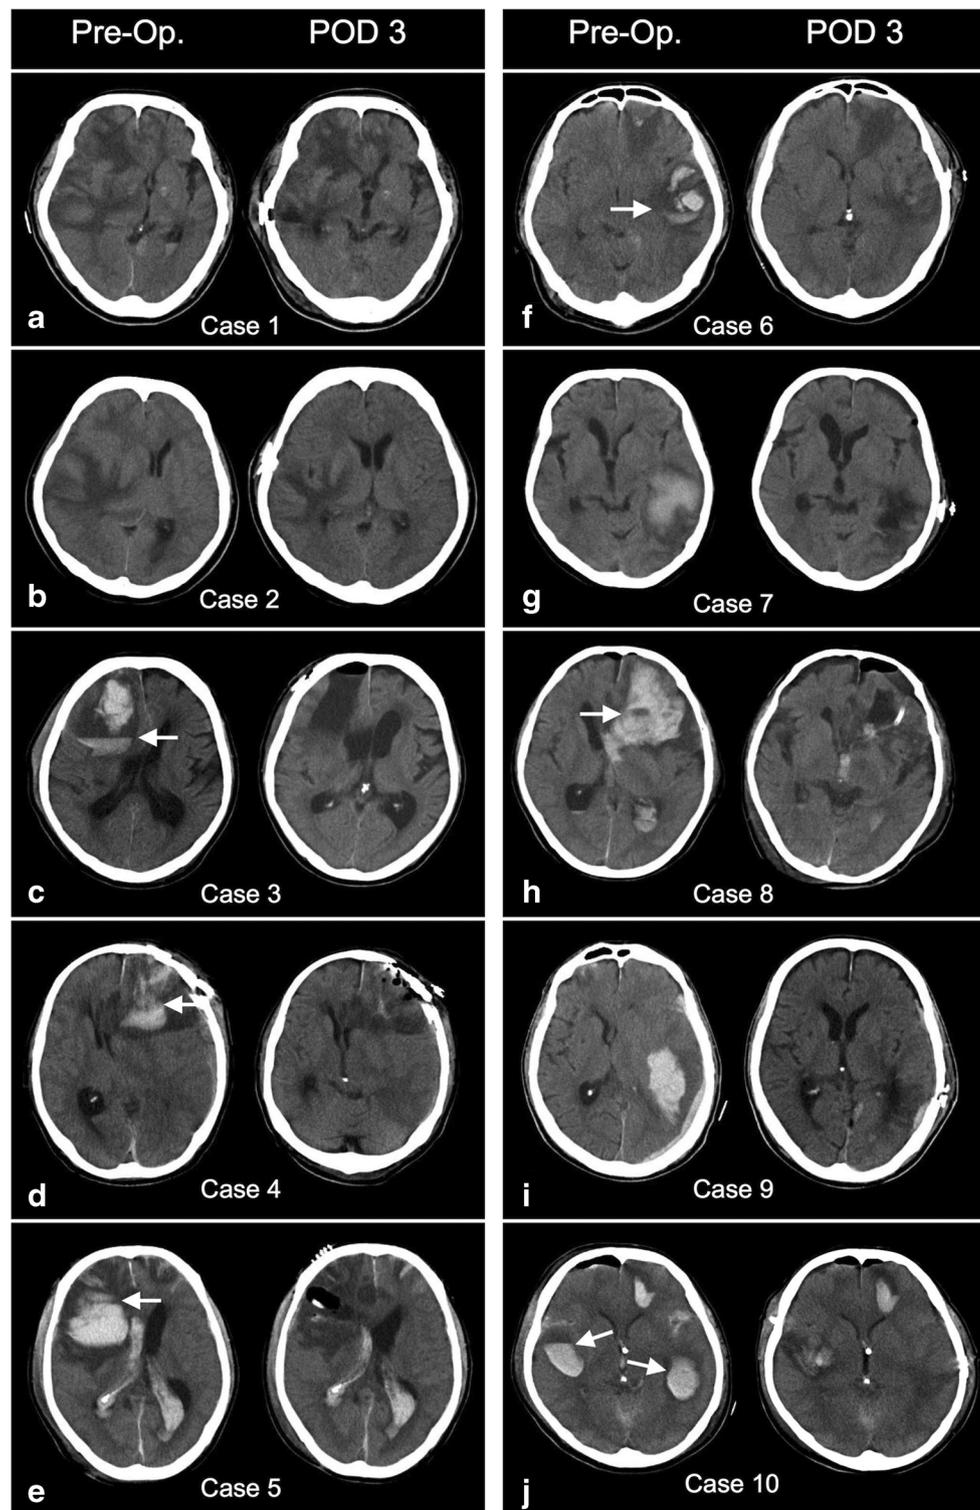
Computed tomography (CT) scans for our present patients taken preoperatively (left) and 3 days after endoscopic surgery (right). Arrows show the blood-fluid interfaces. Sufficient reduction in contusional edema was obtained within 3 days after neuro-endoscopic surgery. a Case 1, a 71-year-old man with right temporal lobe contusion, and surgery at day 16 after trauma. b Case 2, a 58-year-old woman with right temporal lobe contusion, and surgery at day 11 after trauma. c Case 3, a 70-year-old man with right frontal lobe contusion, and surgery at day 10 after trauma. d Case 4, an 85-year-old man with left frontal lobe contusion, and surgery
